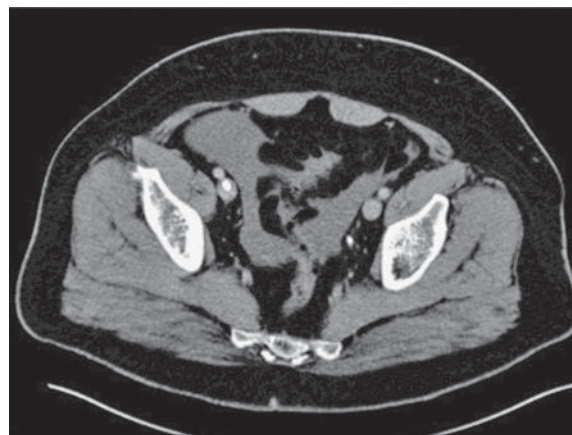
Axial CT scan in the lower abdomen. The calculus in the left ureter is visible as a high density focus. There is also free fluid in the peritoneal cavity.
